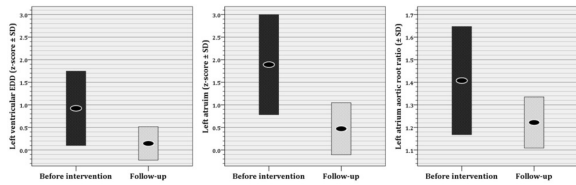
Echocardiographic findings before intervention and during follow-up
